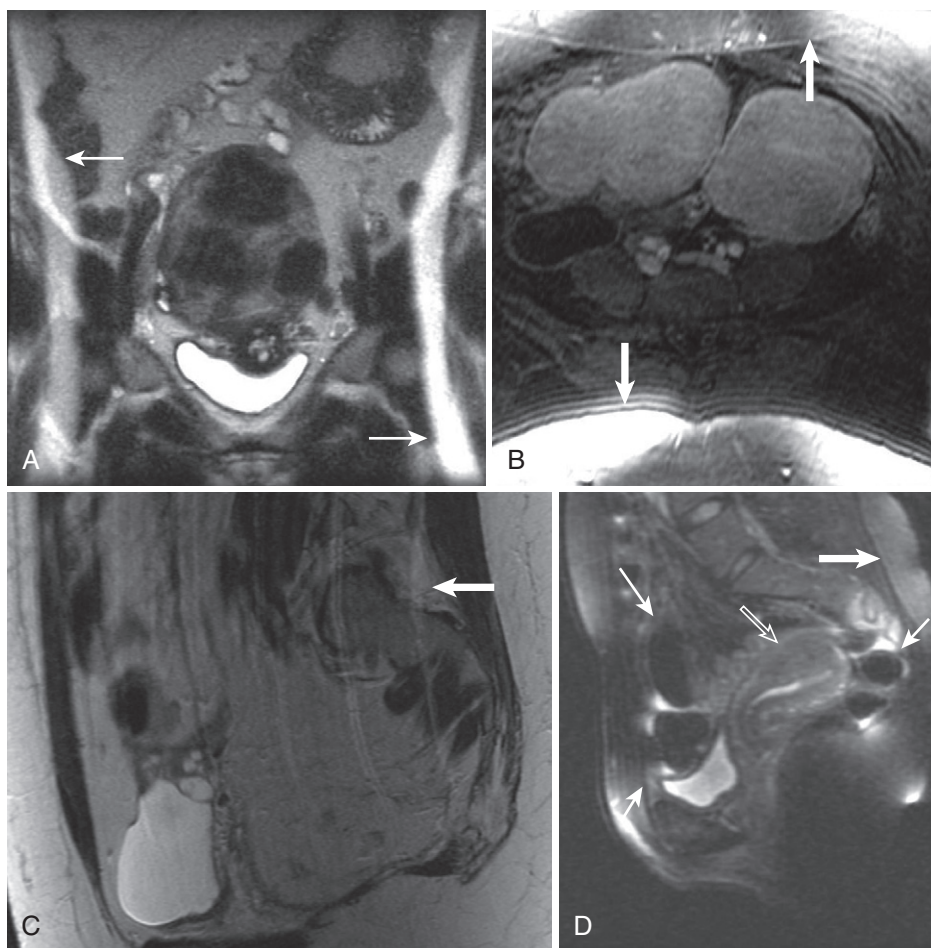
Image degradation due to artifacts. A and B, Coronal T2-weighted (A) and axial T1-weighted fat-saturated gradient echo (B) images depict wraparound artifact along the phase encoding axis (arrows in A and B), which do not obscure underlying anatomy and reflect selection of a small field of view resulting in aliasing of subcutaneous fat. C, Sagittal T2-weighted image mildly degraded by breathing motion artifact along the phase encoding axis (arrow). D, A combination of susceptibility artifact (thin arrows) and failure of fat suppression (thick arrows) degrades this sagittal T2-weighted fat saturated image in a patient with a focal fundal adenomyoma (open arrow).
